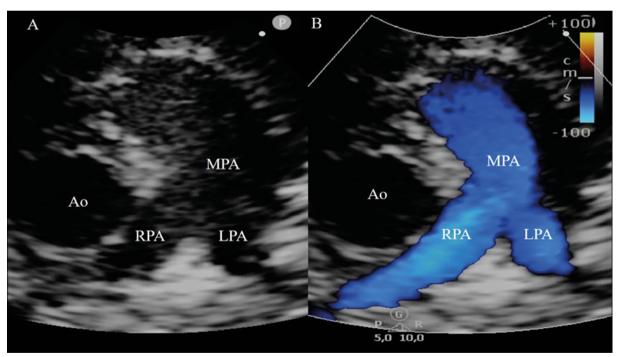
Echocardiographic projections to assess the pulmonary trunk and branches in 2 dimensions (A) and with color Doppler (B). Ao: Aorta; MPA: Pulmonary trunk or main pulmonary artery; LPA: Left pulmonary branch; RPA: Right pulmonary branch.
